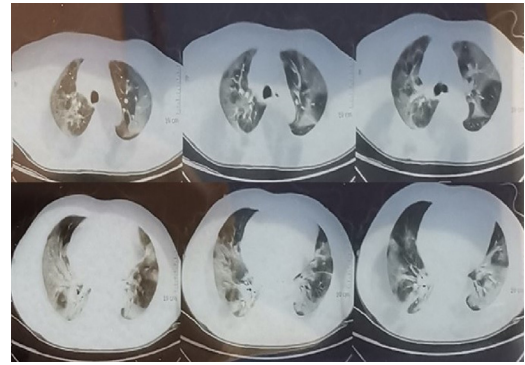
Chest CT images on February 20th. Chest CT images showed a wide range of confluent ground-glass opacities about pleura and fissure in peripheral bilateral lungs. CT, computed tomography.
